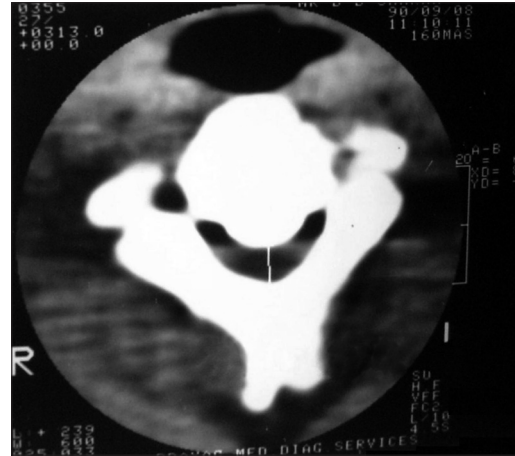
Preoperative CT scan cervical Spine done 20 years back reveals – spinal canal narrowing due to thickening/ossification of posterior longitudinal ligament at C2 vertebral level
